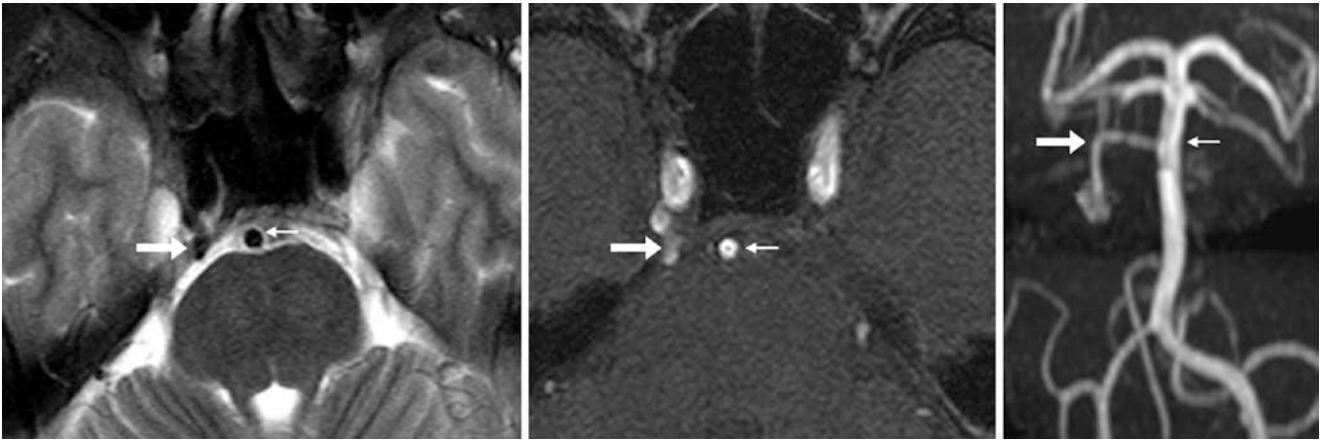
In this 56-year-old, a T2WI MRI (*left*) shows a persistent trigeminal artery (PTA) (*large arrows*) that arises from the cavernous right internal carotid artery (ICA) and travels lateral to the sella, tapering in size as it approaches the mid-basilar (*thin arrows*). This PTA is
